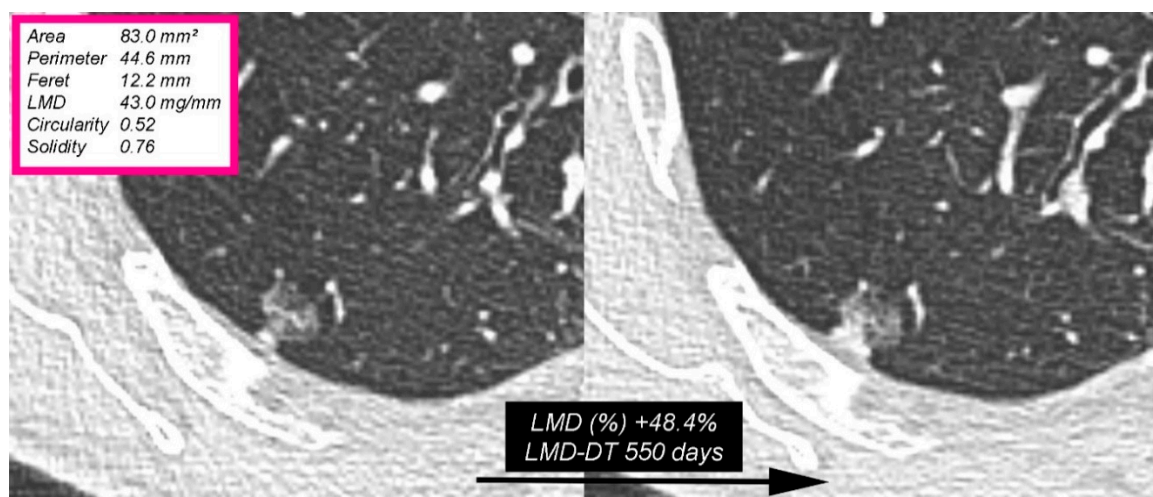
Growing part-solid nodule (PSN) in the right upper lobe in a 78-year-old man with a previous smoking and oncologic history. The PSN exhibits a mushroom shape. The interval between the baseline (left) and last follow-up CT scan (right) was 313 days. The computerized analysis showed a significant relative linear mass density (LMD) variation of +48.4% in the nodule with an LMD-doubling time (LMD-DT) of 550 days. The purple box (top left) shows the main quantitative features obtained from the baseline CT image.
